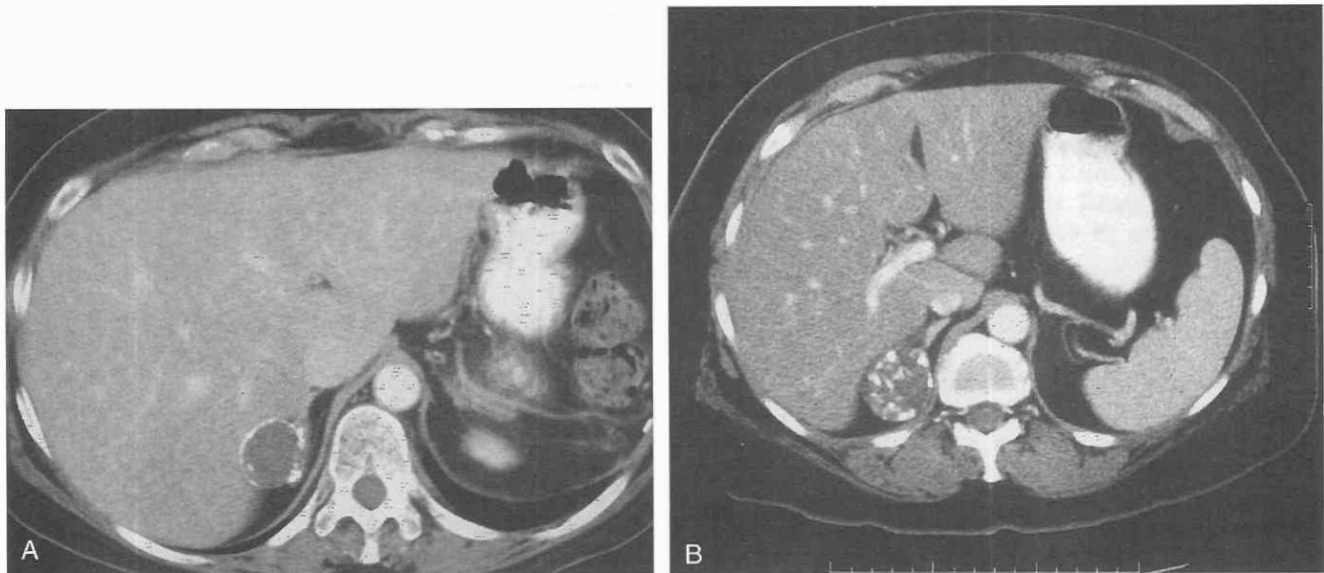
Adrenal pseudocysts. *A* and *B*, Contrast-enhanced CT scans of two patients reveal nodular calcification in right adrenal cystic lesions. These lesions, which remained stable over several years, were thought to represent adrenal pseudocysts resulting from previous trauma.
